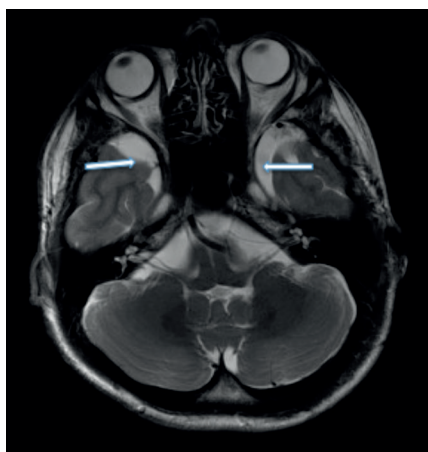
Axial T2-weighted sequences brain, (patient 2 aged 26), demonstrating bilateral middle cranial fossa arachnoid cysts.
